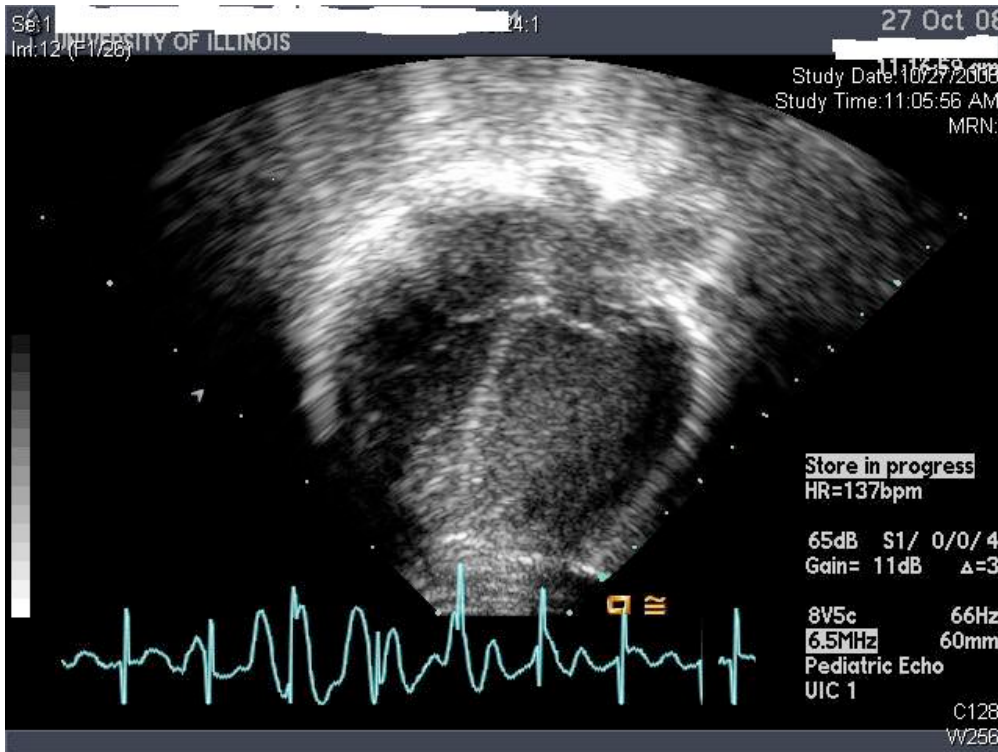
Two-dimensional echocardiogram during follow-up showed no evidence of pericardial effusion.
